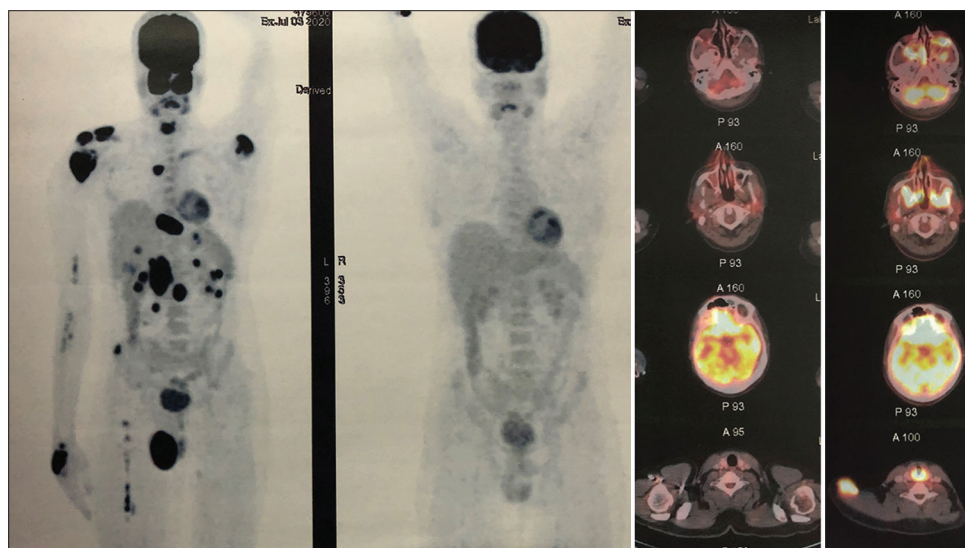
PET CT showing lymphoma metastasis before and after chemotherapy
